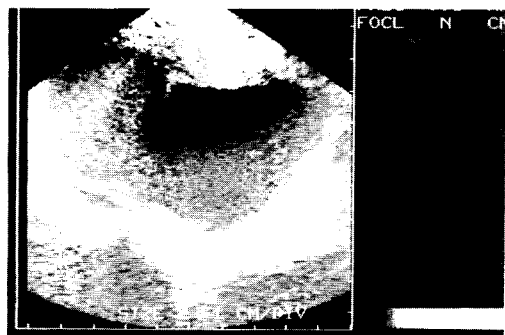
Vaginosonographical scan of an ovarian endometrioma with cloudy structures easy to be differentiated from other ovarian tumours
